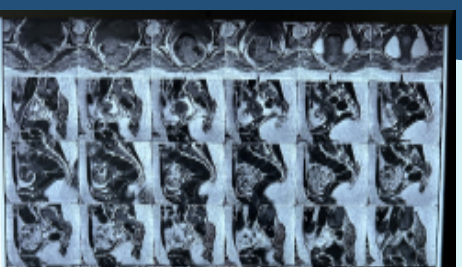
MRI Abdomen and pelvis
